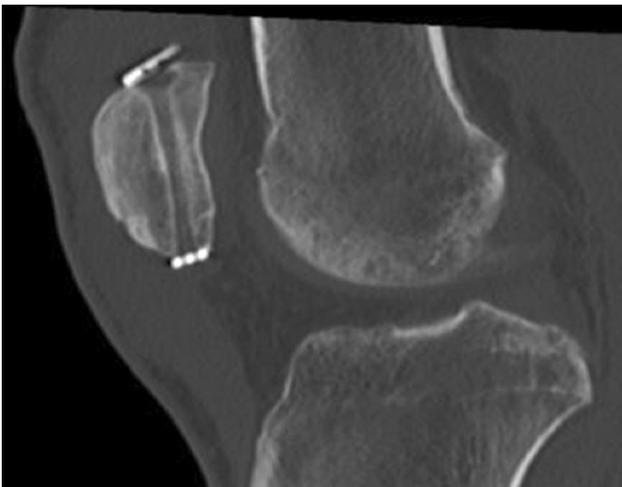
Sagittal CT scan image depicting a distal patellar knee fracture
